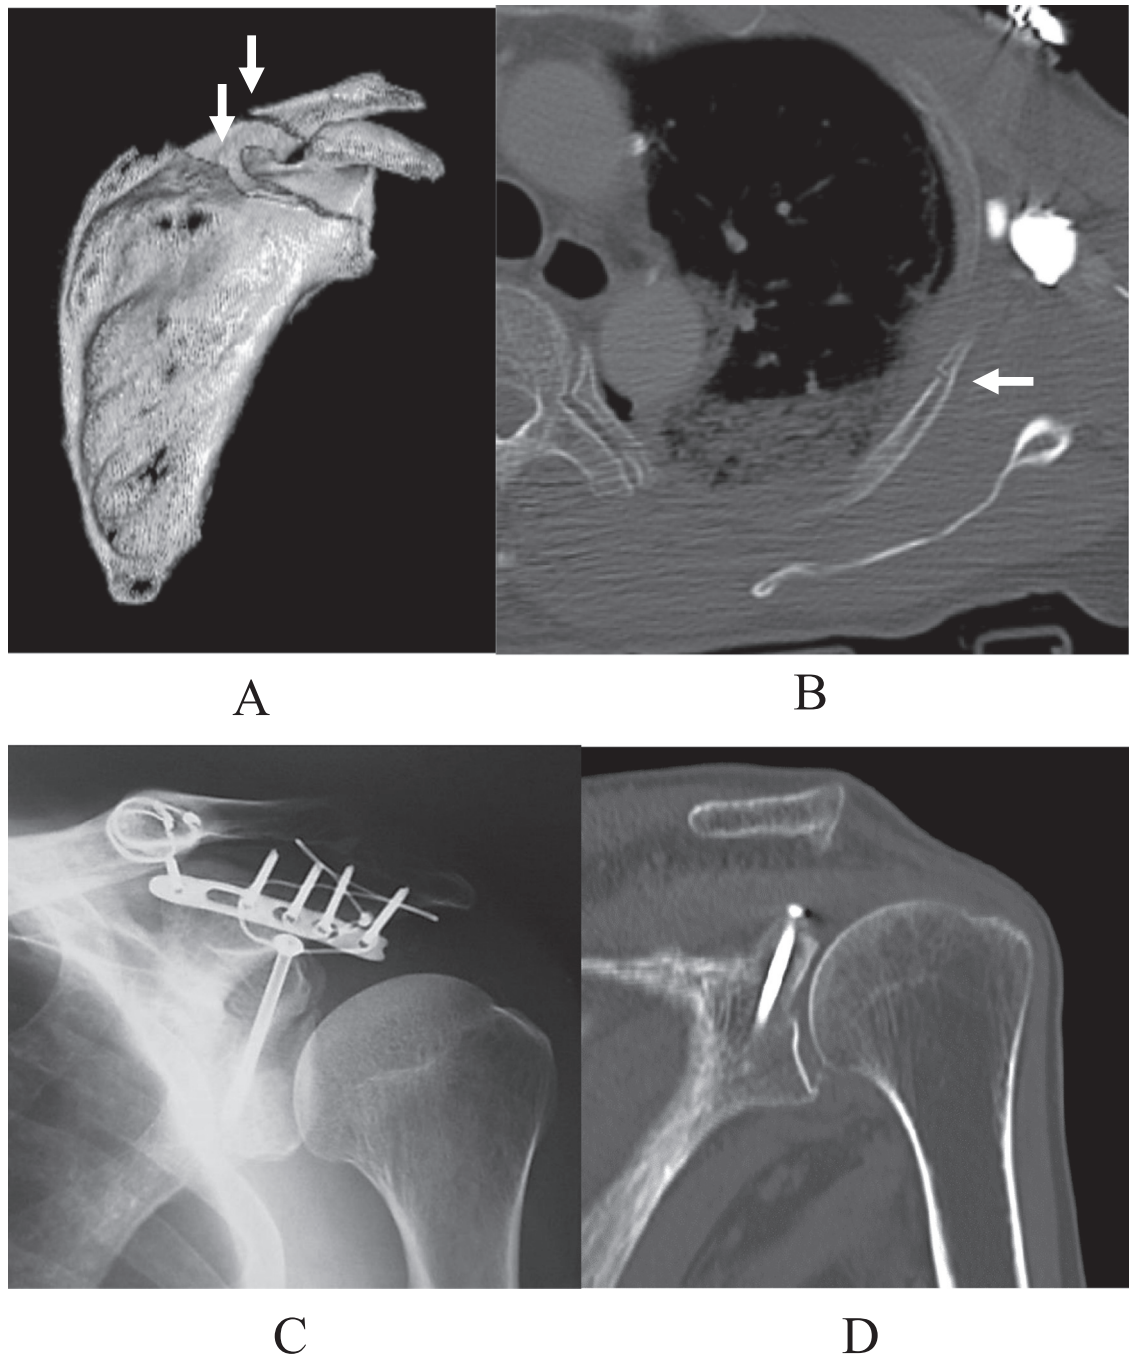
A 71-year-old male. A) Three-dimensional CT demonstrating left Ideberg type III glenoid fracture and acromion fracture. B) Axial CT demonstrating fracture in the left fourth rib. The left third and ninth ribs were also fractured. C) Anteroposterior radiograph 43 months after surgery demonstrating no degenerative changes in the left shoulder joint. D) Coronal CT demonstrated bone union.
